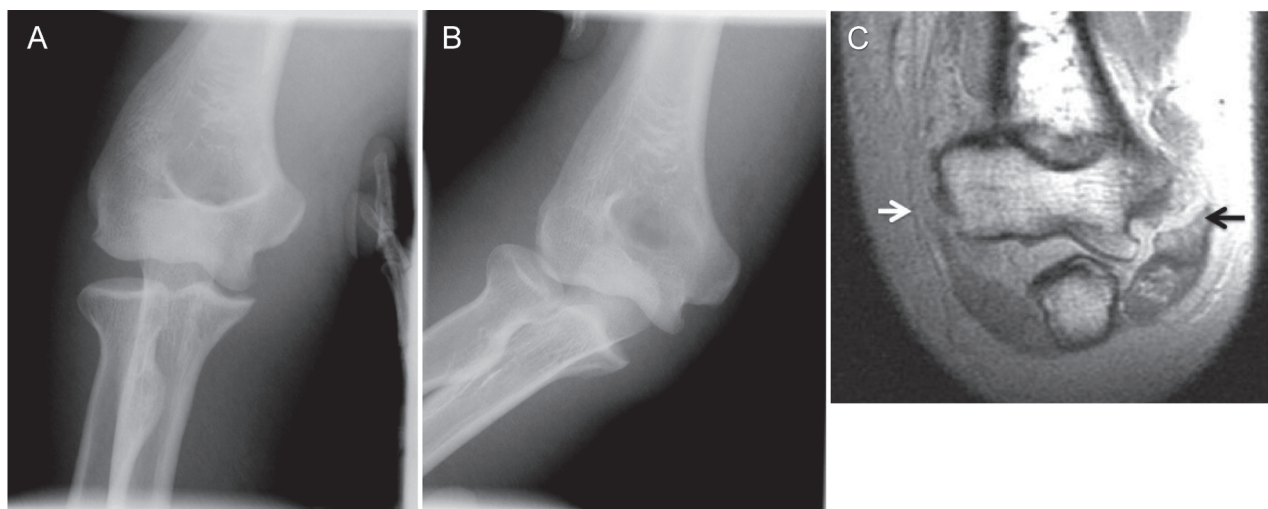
Stress radiographs (A) (B) and magnetic resonance imaging (C) of the right elbow. Stress radiographs showing both: (A) varus and (B) valgus instabilities. T1-weighted magnetic resonance imaging (C) showing the mid-substance tear of the medial collateral ligament (black arrow) and the avulsion of the lateral collateral ligament from its attachment to the lateral humeral epicondyle (white arrow).
